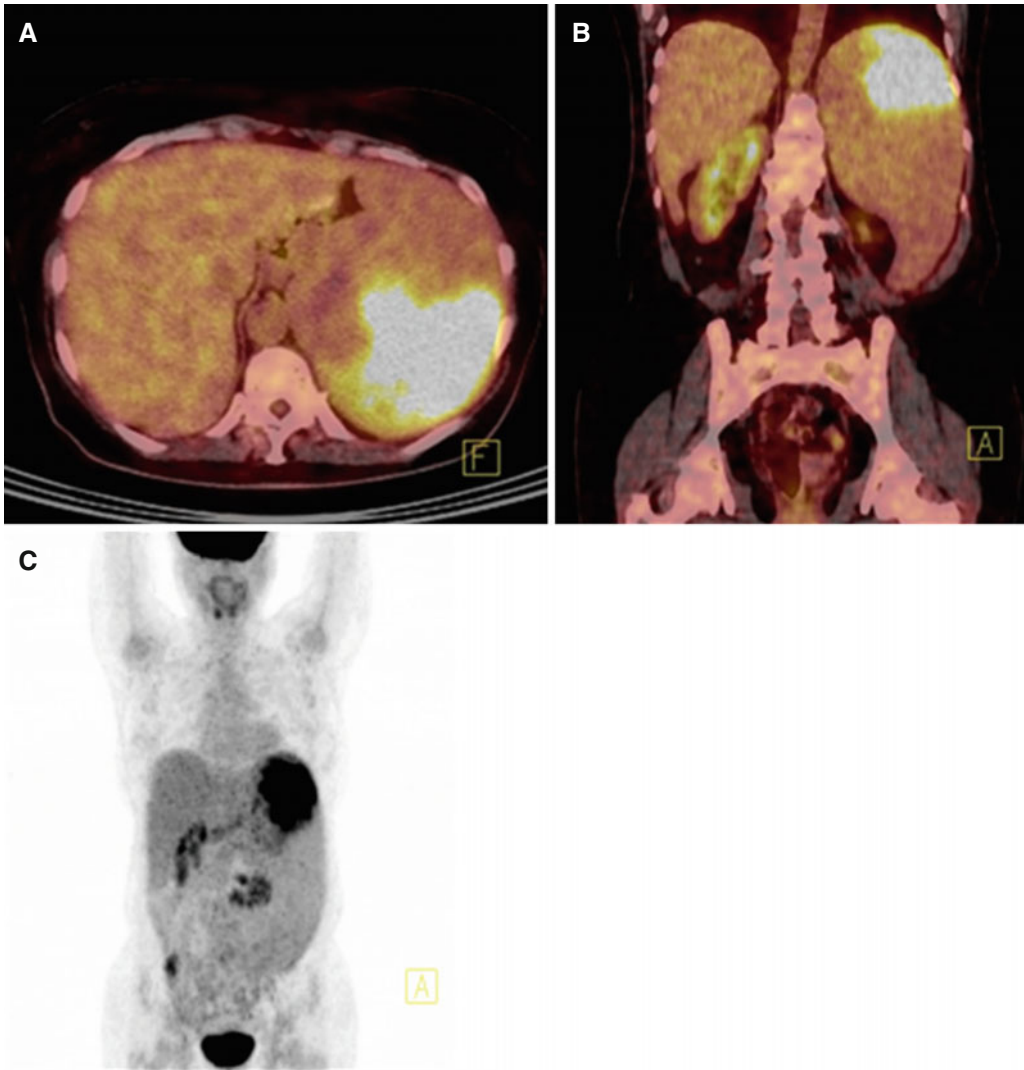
In axial and coronal PET/CT images (A, B) and PET MIP image (C), an area of increased FDG uptake is seen in the upper pole of the enlarged spleen (SUVmax 9.5)
